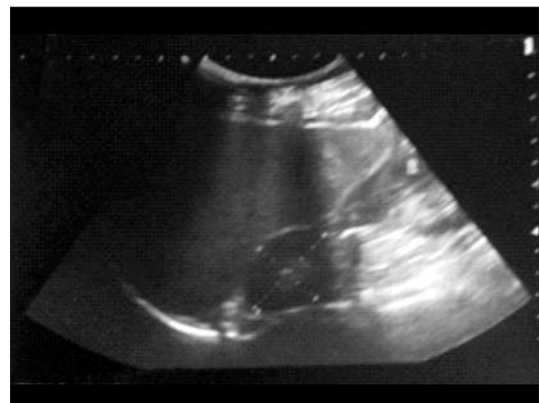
Preoperative ultrasound image
